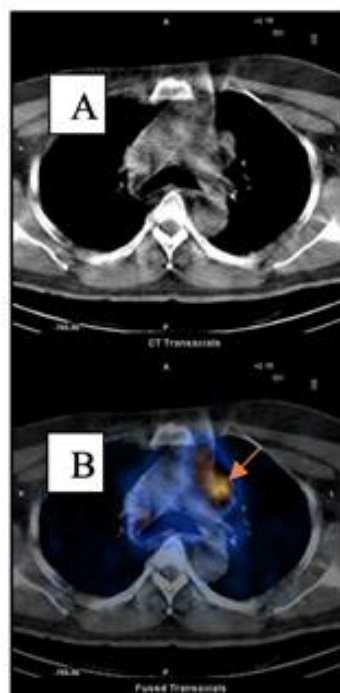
A, CT of the thoracic region, B, Fused SPECT/CT image of thoracic region revealing tracer uptake in the pericardial cavity
